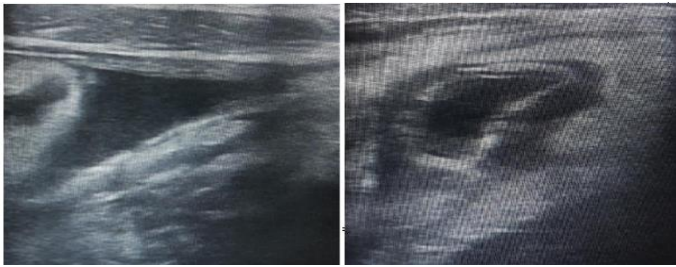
High-frequency ultrasound in 50 years old patient with acute abdomen shows thickened and dilated non-compressive blind-ended tubular structure showing few focal hypoechoic defects in its wall associated with mild hypoechoic fluid in RIF region and adjacent echogenic inflamed mesentery suggestive of acute appendicitis with perforation.
